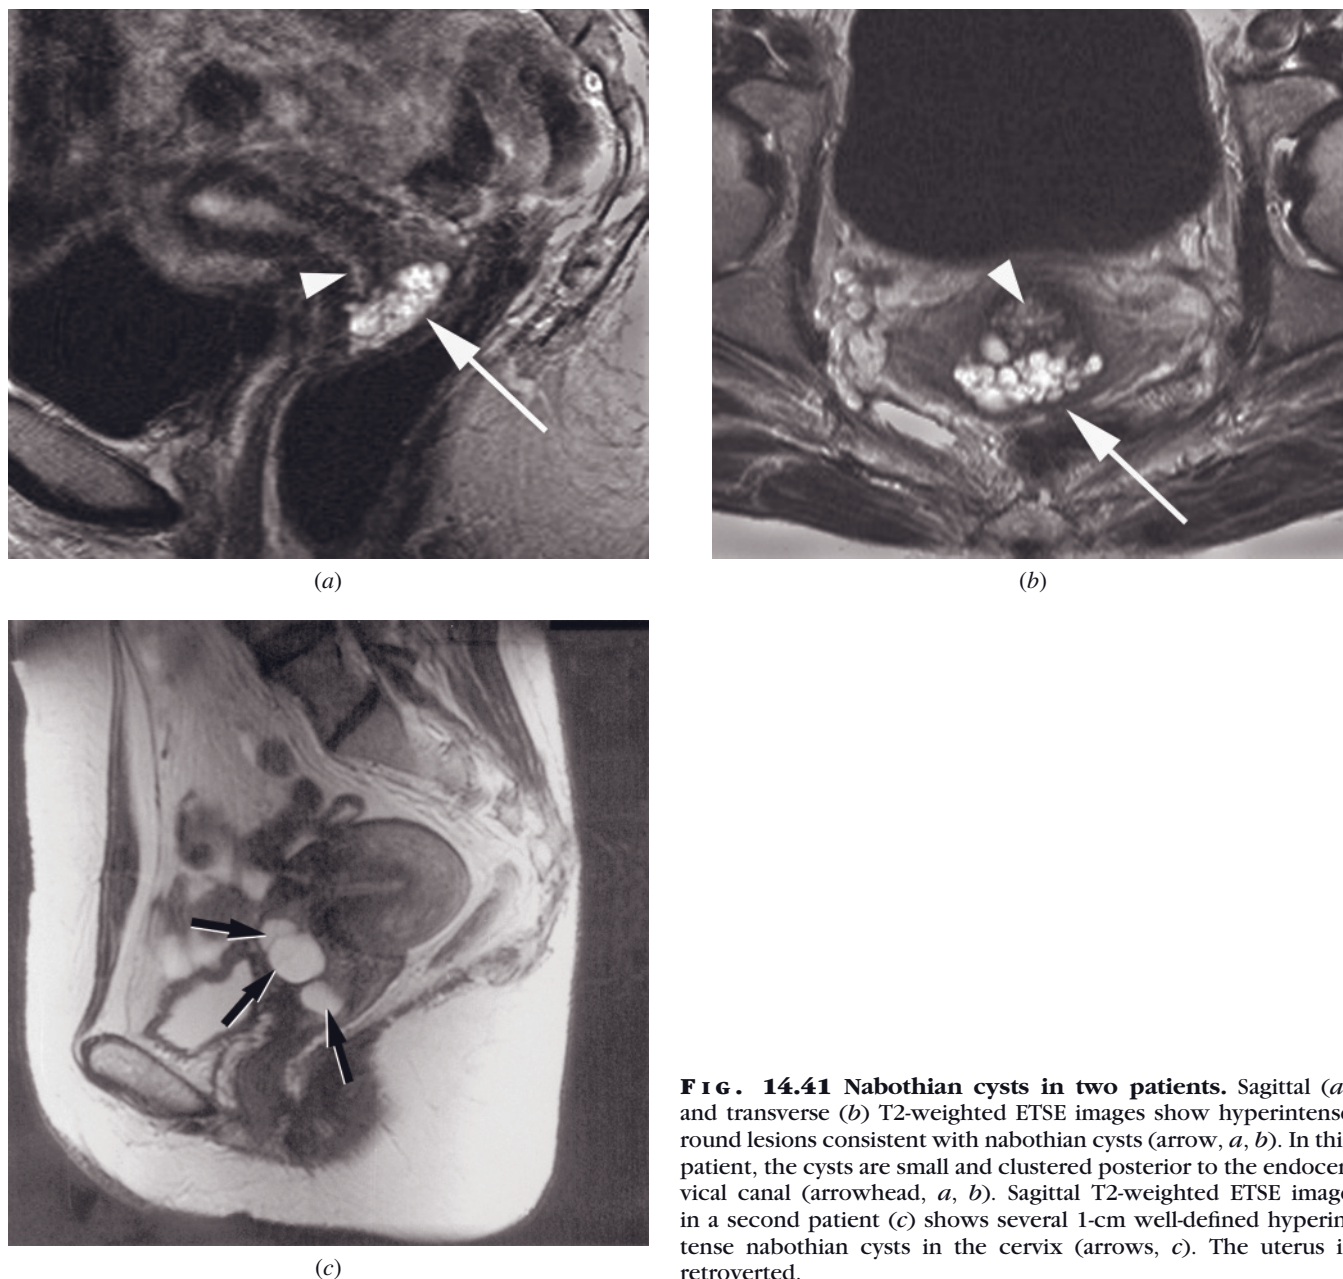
Nabothian cysts in two patients. Sagittal (a) and transverse (b) T2-weighted ETSE images show hyperintense round lesions consistent with nabothian cysts (arrow, a, b). In this patient, the cysts are small and clustered posterior to the endocervical canal (arrowhead, a, b). Sagittal T2-weighted ETSE image in a second patient (c) shows several 1-cm well-defined hyperintense nabothian cysts in the cervix (arrows, c). The uterus is retroverted.
